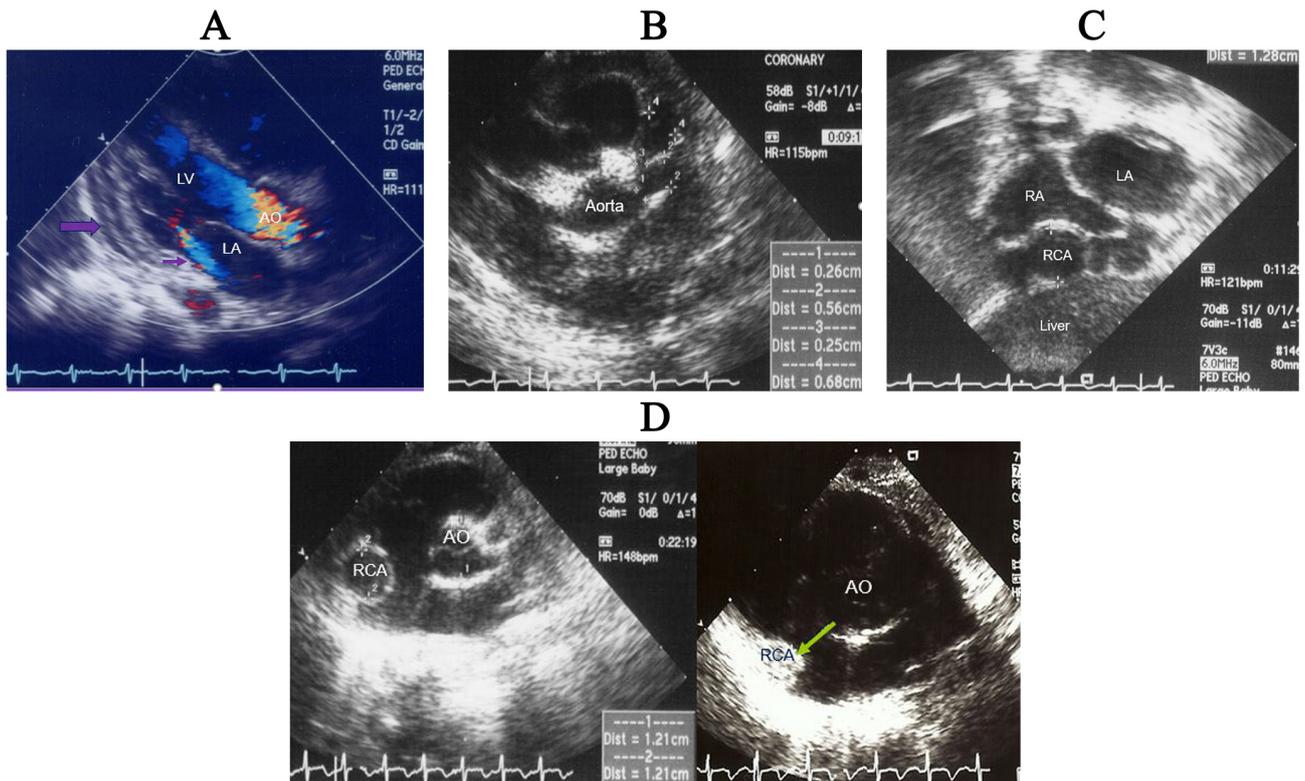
Echocardiographic images of a 3-month-old infant with KD. Parasternal long axis view with color Doppler showing mitral valve regurgitation (small arrow) and pericardial effusion (Large arrow) (A), parasternal short axis view showing fusiform coronary aneurysms of the left coronary arteries (B), modified subcostal view showing giant coronary aneurysm of the right coronary artery (C) and parasternal short axis view showing right coronary giant aneurysm of which inner diameter is as large as aorta (left) and complete intraluminal occlusion (arrow) 1 year later (right) (D). (B,C) are reproduced with permission from [68]. KD, Kawasaki disease; LV, left ventricle; LA, left atrium; AO, aorta; RA, right atrium; RCA, right coronary artery.
